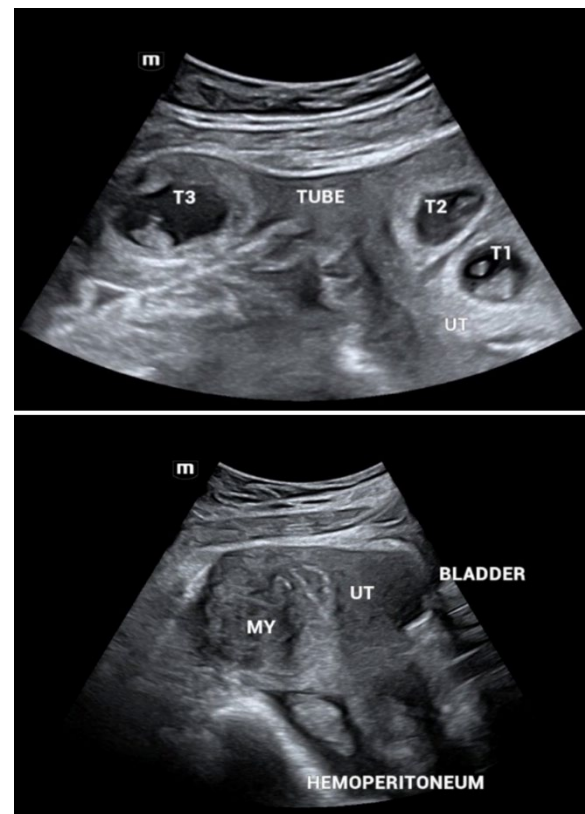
Ultrasound findings: A shows three gestational sacs, two of which are intrauterine (UT) twins (T1, T2) and one in the right tube (T3). B shows a sagittal section of the pelvis. A posterofundal fibroid (MY) and an effusion in the Douglas suggesting hemoperitoneum
